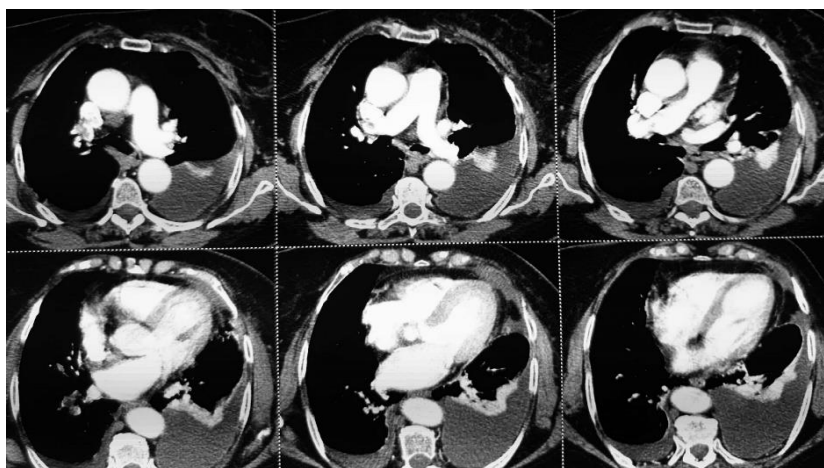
CT chest angiography showing a right pulmonary artery embolism.
